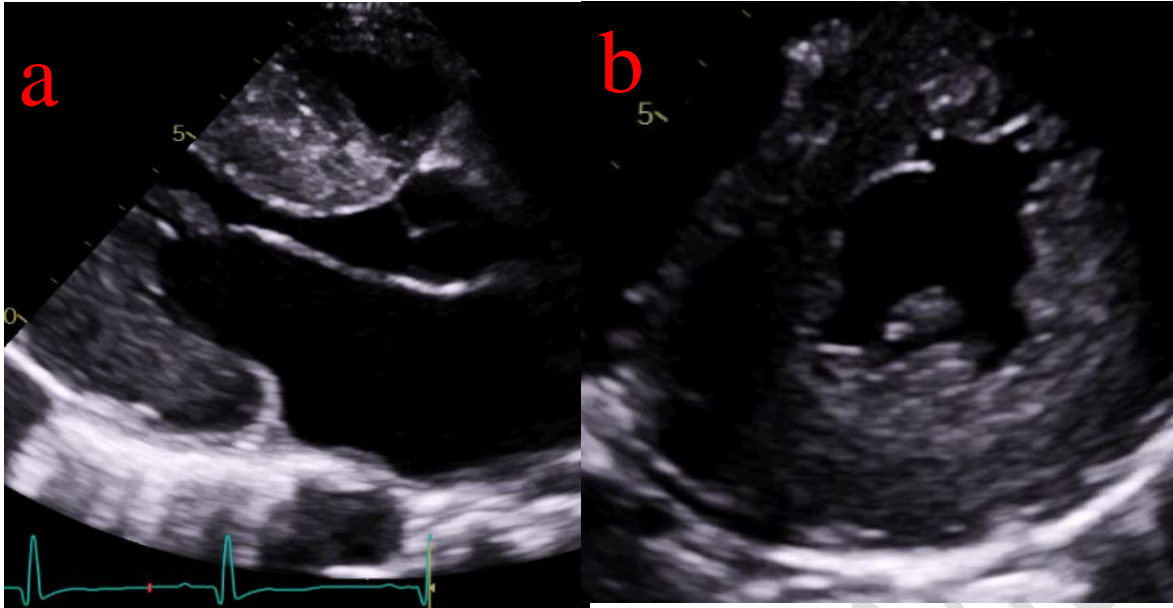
TTE: parasternal long axis view: showing hypertrophy of the LV and systolic anterior motion of the mitral valve leaflet.
